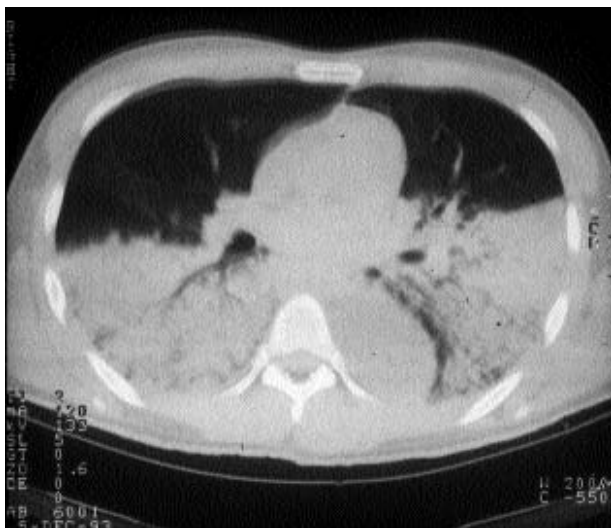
Adult respiratory distress syndrome (ARDS) lungs in a 24 year old male with polytrauma, lung contusion and massive aspiration. a) In the chest radiograph diffuse, homogeneous oedema is apparent in both lungs. b) The computed tomography (CT) scan from the same day demonstrates the inhomogeneous distribution: fluid-filled, nonaerated areas are visible in the dependent parts of the lungs, whilst the nondependent parts are aerated.
